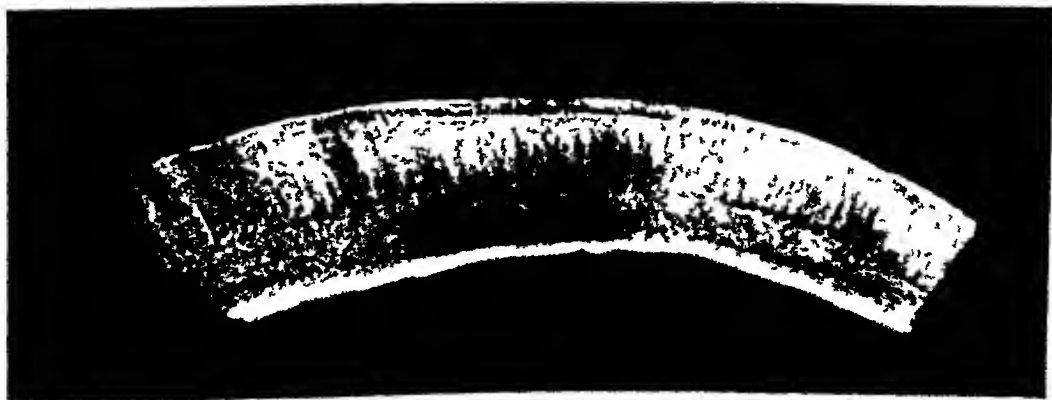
Roentgen-ray appearance of ground section of bone 0.5 mm. thick, showing dense internal laminae, next to this, the ordinary diploë and external as well as new bone laid down in vertical columns.
